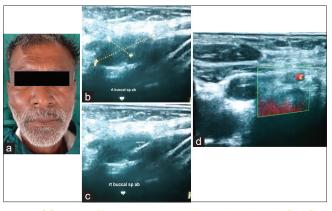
(a) Front profile view showing swelling on the right side of the face (b) USG image depicting homogenous anechoic impression of Right Buccal space abscess (c) USG image depicting homogenous anechoic impression of Right Buccal space abscess with needle (d) Color Doppler image depicting the vascularity adjacent to the abscess
